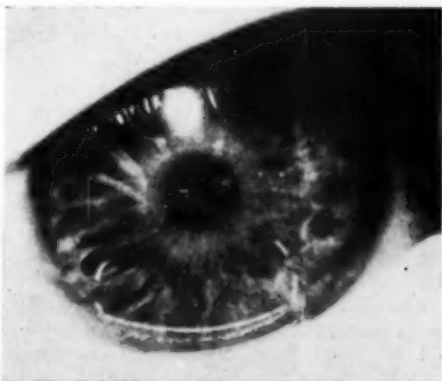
(Hedges). Complete regression of the lesion three months after superficial X-ray therapy.
